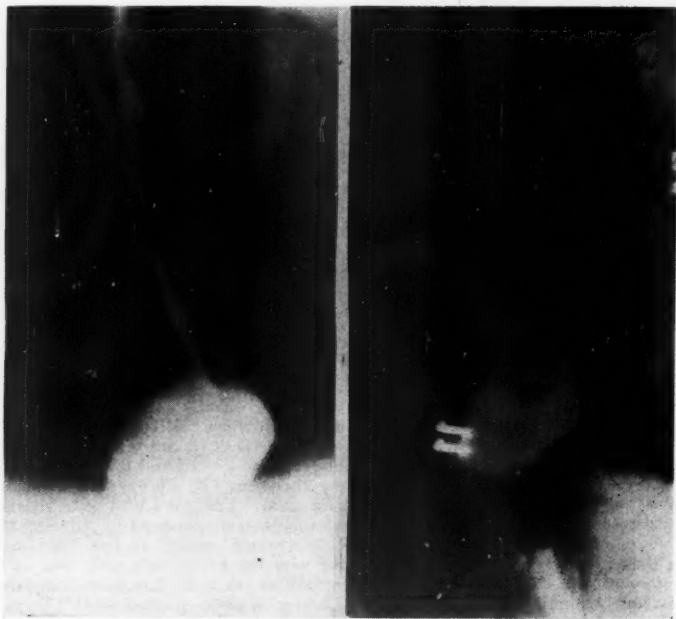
X-rays of the esophagus following a barium swallow. Left, before operation. Right, three weeks following operation.
